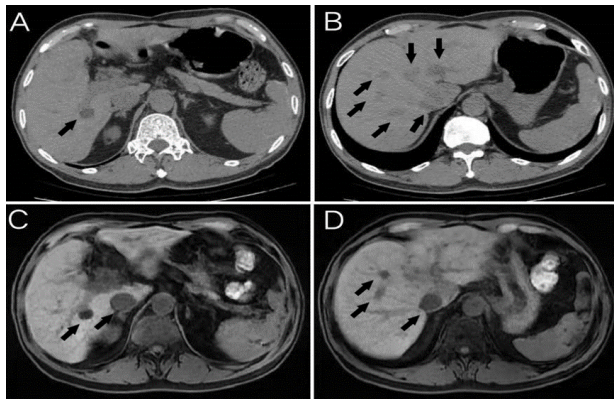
Abdominal CT revealed multiple round hypodense nodules in the liver (A, B arrowhead). Hepatic MRI revealed multiple round T2 hyperintensity nodules in the liver (C, D arrowhead).
